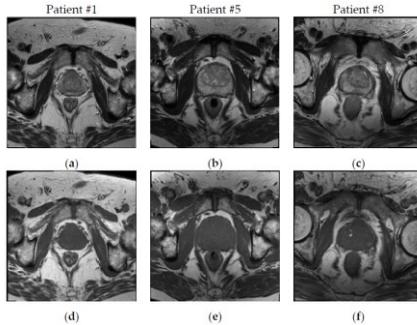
Three instances of input MRI axial slice pairs for the Patients #1, #5 and #8: (a-c) T1w MR images; and (d-f) corresponding T2w MR images.
